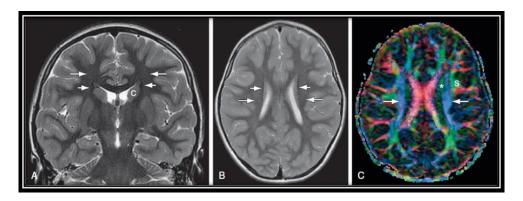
Corona radiata, (long white arrows) are shown in coronal (A) and axial (B) T2W MR images (C) axial DTI color map. The fibers (white arrows) of the coronal radiata are identifiable medial to the fibers of the SLF (s) (*Quoted from Naidich et al.*, 2013).
